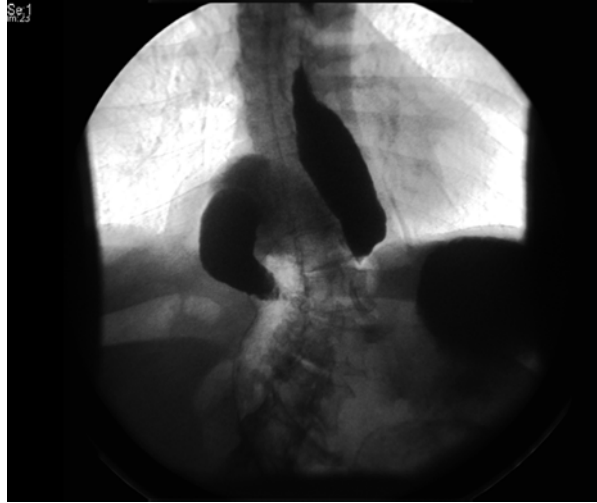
A chest X-ray (anteroposterior view) is shown of a patient suggestive of a hiatal hernia. A barium swallow showed a type III paraesophageal hernia
